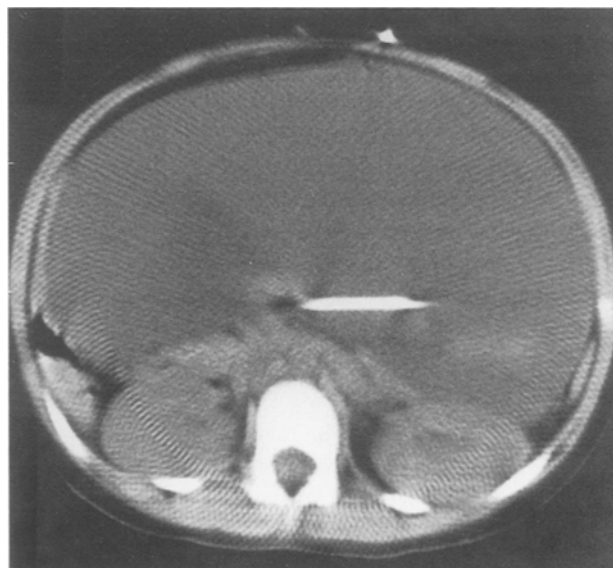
Computerized tomography (CT) image of ventriculoperitoneal shunt and large pseudocyst at level of kidneys
